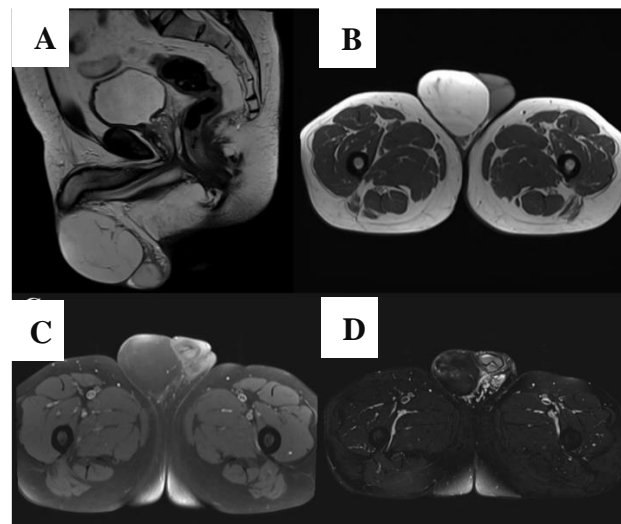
Scrotal MRI. A): Globular shaped right scrotal tumour mass with well-defined margins, poorly vascularized peripherally, B): Scrotal lesion with mostly homogeneous high signal intensity, C) and D): loss of signal intensity on frequency-selective fat-saturated images.
